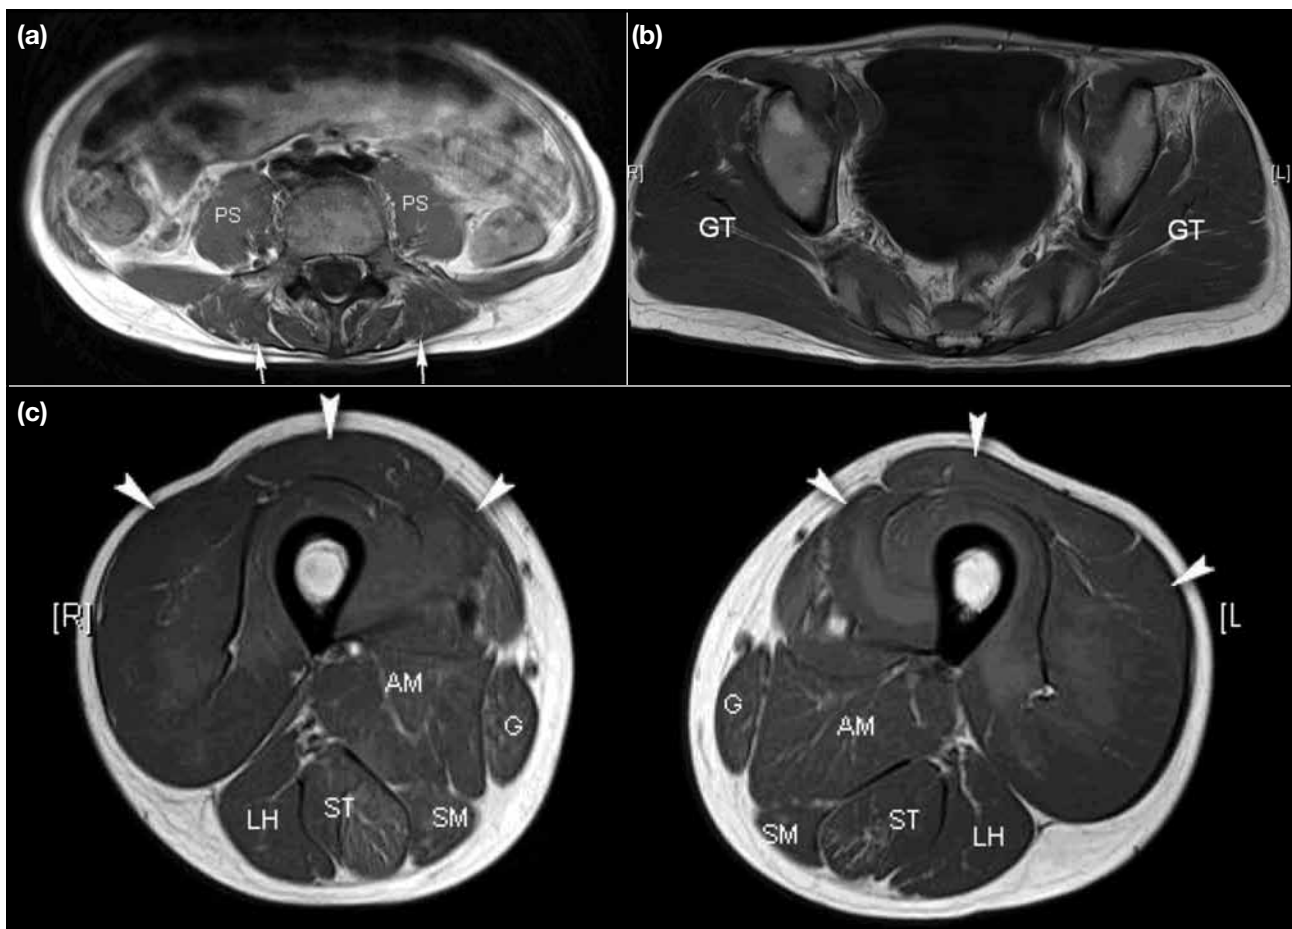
Axial T1-weighted magnetic resonance images of the (a) lower trunk and (b) pelvis of the older brother demonstrating severe fatty infiltration of the paraspinal muscles suggesting stage 3 disease according to Fischer's rating scale (arrows) and stage 2 disease of the psoas and right gluteal muscles (black arrowheads). A moderate degree of muscle atrophy is noted. Note the metallic artefacts along the lumbar spine from posterior spinal fusion. Axial T1-weighted magnetic resonance images of the (c) right and (d) left thighs demonstrating a moderate degree of atrophy suggesting stage 2 disease of the semitendinosus, semimembranosus, and adductor magnus muscles. Involvement of the long head of the biceps femoris, gracilis, and quadriceps muscles (white arrowheads) is mild. Abbreviations: AM = adductor magnus; G = gracilis; LH = femoris; PS = psoas; SM = semimembranosus; ST = semitendinosus.
